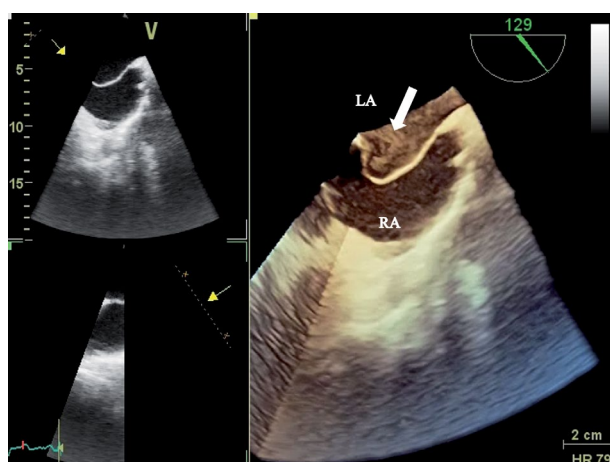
3D transesophageal echocardiogram showing giant atrial septal aneurysm with thrombus (arrow).
